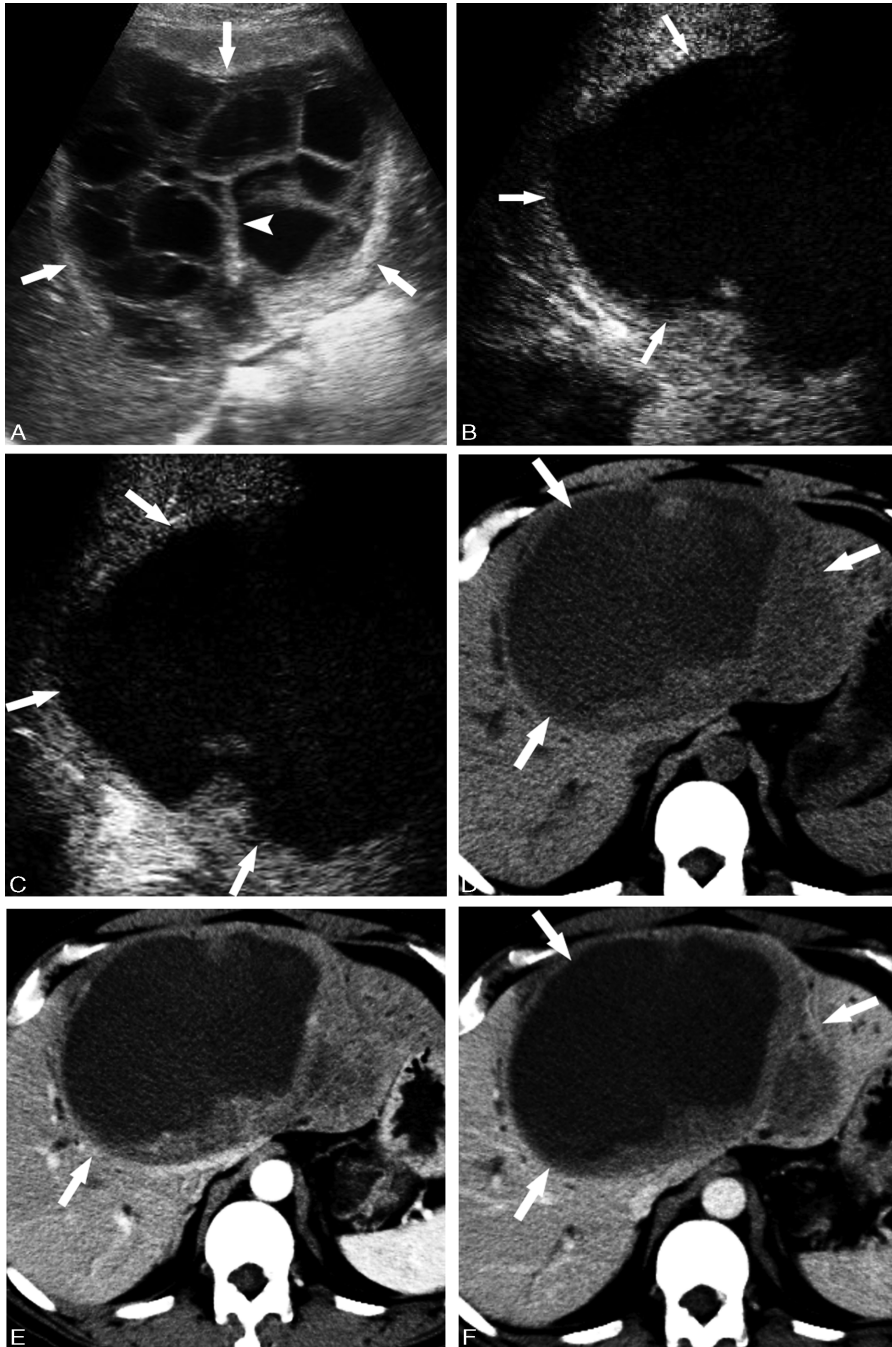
Primary hepatic neuroendocrine tumor in a 50-year-old man (case 2). A, Conventional B-mode ultrasonography revealed a multilocular cystic lesion (arrow) with several septa (arrow head) 13.0 cm in diameter. B, C, Contrast-enhanced ultrasonography obtained at 27 s (B) and 88 s (C) showed hypoenhancement in the arterial phase (B) and iso-enhancement in the periphery and nonenhancement in the center in the portal venous phase (C). CT revealed a well-circumscribed, heterogeneous, hypodense lesion in the plain phase (D) and hypoenhancement in both the arterial (E) and portal venous phases (F).
